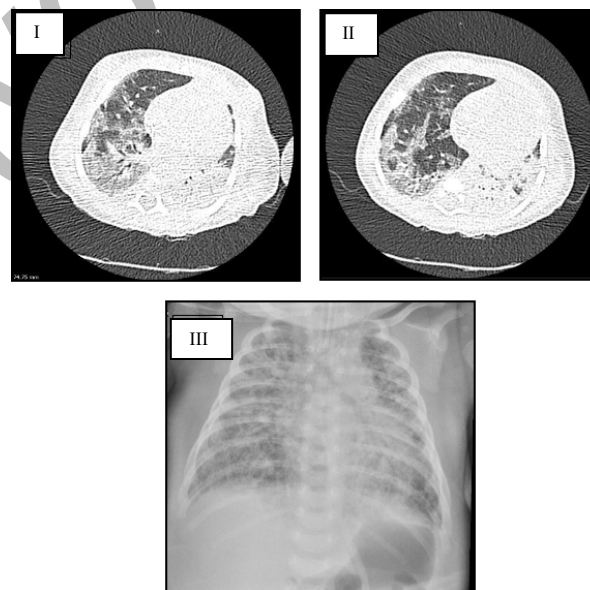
Chest computed tomography. Computed tomography (I and II) showing ground-glass opacities with reticulation (mosaic), multifocal, predominantly peripheral, affecting 50–75% of the parenchyma, accompanied by consolidations, typical alterations of viral pneumonia. Chest X-ray (III) showing diffuse
